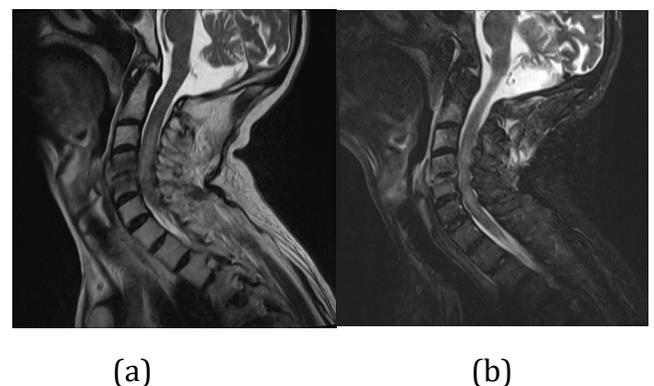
T2-weighted (a) and STIR sagittal images show myelopathy due to compression of the dural sac and bone marrow changes as a sign of the post-irradiation osteonecrosis.
